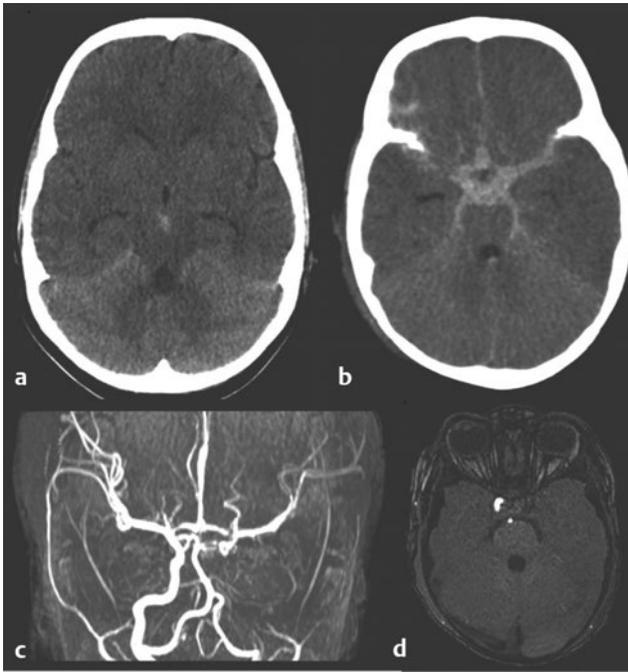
Traumatic subarachnoid hemorrhage. (a) Small amount of subarachnoid blood in the interpeduncular fossa (traumatic). (b) A more substantial traumatic subarachnoid hemorrhage. (c,d) Computed tomographic angiograms of the patient in (b), demonstrating absence of the left carotid.
